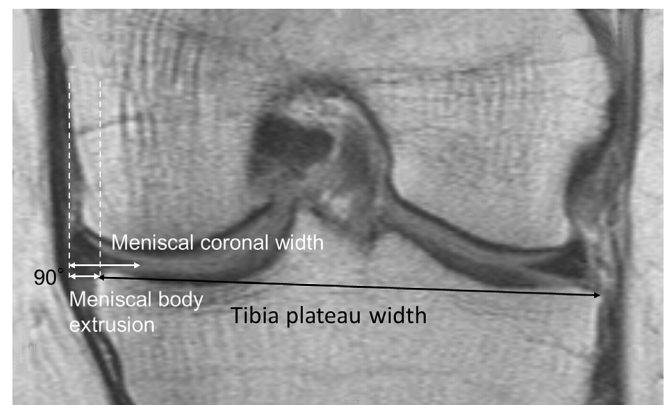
Example of measurements on mid-coronal 1.5 T intermediate weighted knee magnetic resonance images using Sante DICOM Editor (the two dashed white vertical lines perpendicular to the tibial plateau mark the edge of the tibial plateau and the peripheral border of the meniscus body, respectively).
